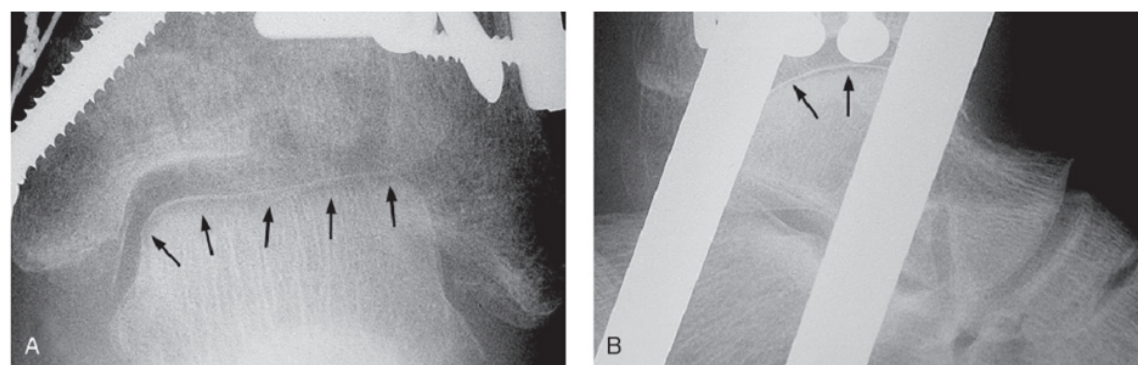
The Hawkins sign in a woman who had undergone external and internal fixation of a complex pilon fracture. Mortise view (A) and lateral (B) radiographs of the ankle reveal striking subchondral radiolucency (arrows), indicating talar viability.
